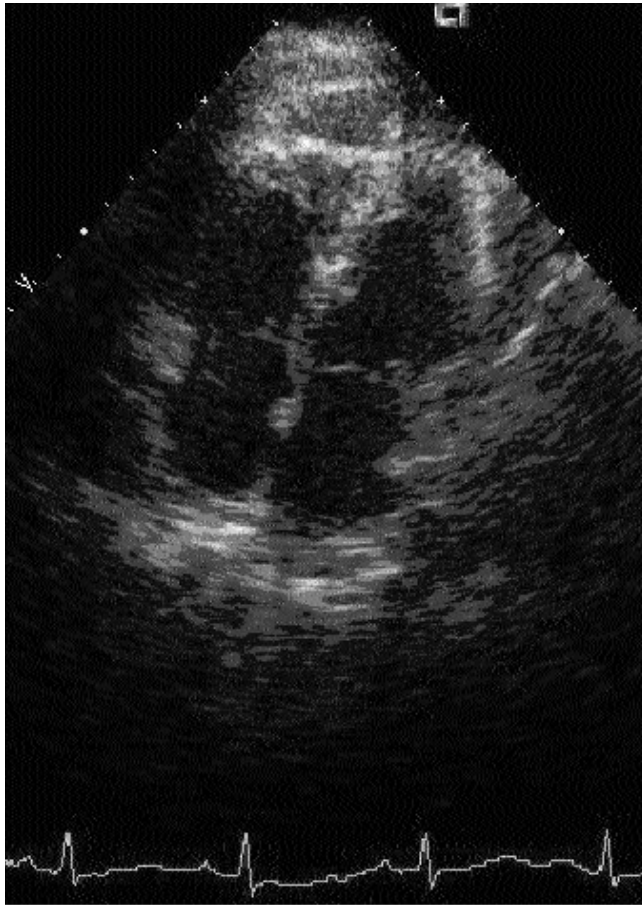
Transthoracic echocardiogram, apical four chamber view showing dilated right atrium and right ventricle.
